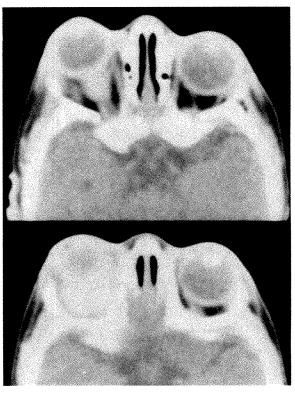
(Munoz and Weatherhead). Axial computed tomography of orbits shows right extraconal and intraconal mass.
